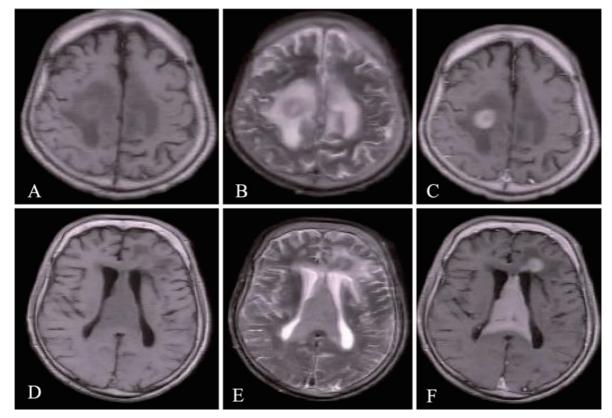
Preoperative brain magnetic resonance imaging scans: T1-weighted images (A and D), T2-weighted images (B and E), and gadolinium-enhanced T1-weighted images (C and F). The tumors were isointense on T1-weighted images and moderately hyperintense on T2-weighted images. The contrast medium was distributed uniformly and markedly. Brain edema was noticeable near the tumors, and the corpus callosum was extensively enhanced.
